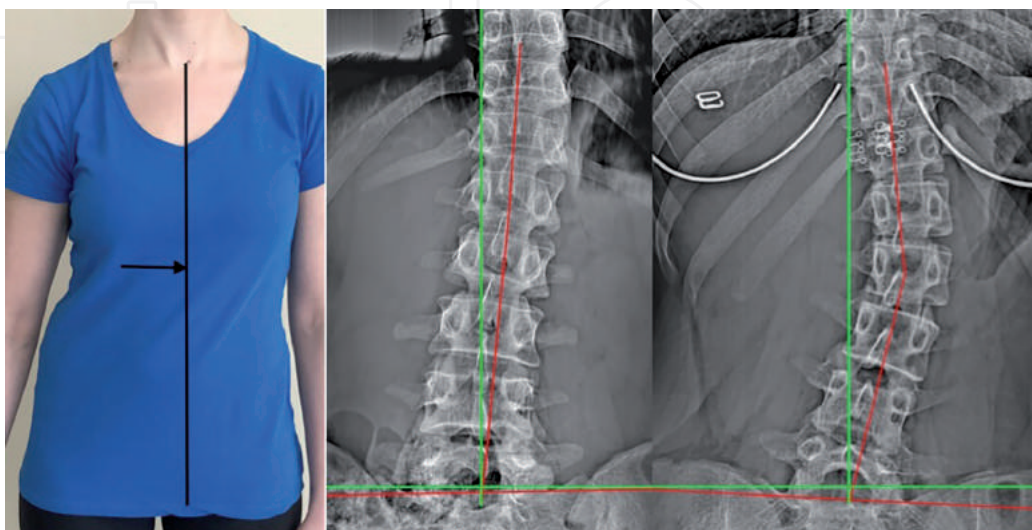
Posture image and antero-posterior lumbar radiographs depicting a left lateral thoracic translation (side shift). Both patients in the radiographs have a 20 mm left lateral shift of T10 off midline. Left patient has a pure left lateral thoracic translation posture, aka ‘pseudo-scoliosis.’ Right patient has a true left lumbar scoliosis (vertebral rotation). Green line is vertical; red line highlights patient alignment (courtesy CBP seminars).
